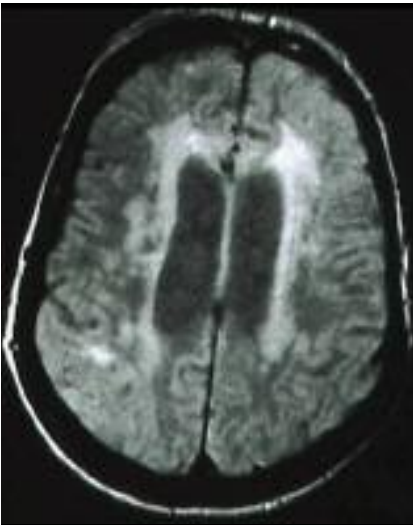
FLAIR MRI image showing white matter changes with acute cerebral infarction in the right posterior parietal lobe.
